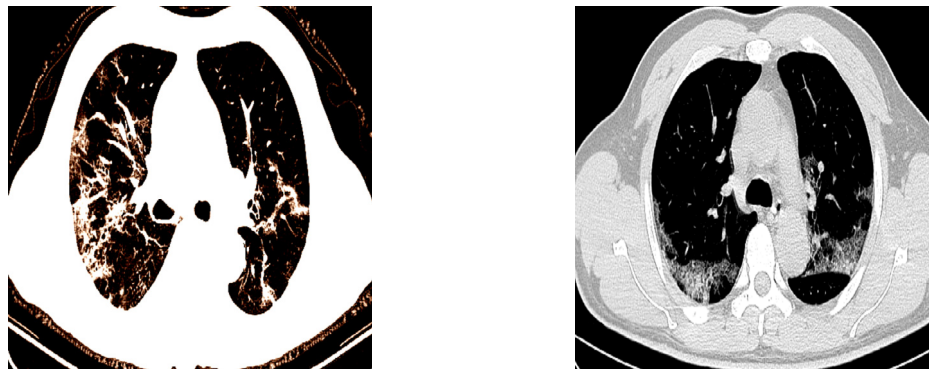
Example CT-scan images from the training dataset of all 3 classes.
